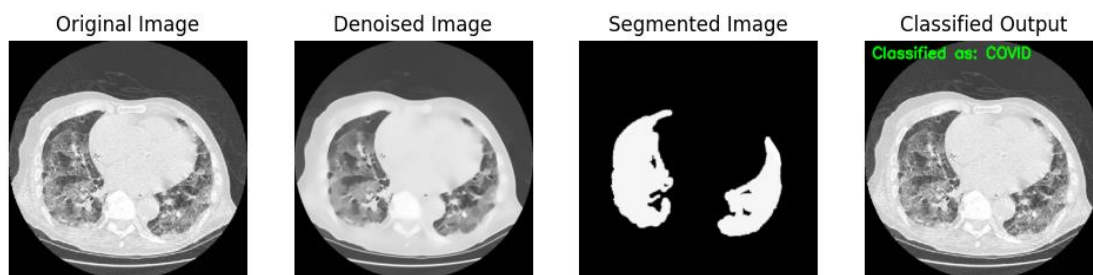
Predicted Outcome as COVID-19 by Proposed CT-CXR-Net.
